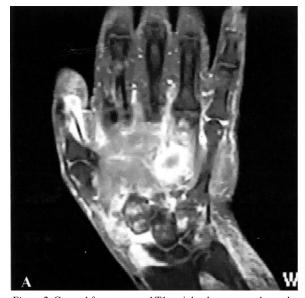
Coronal fat-suppressed T1-weighted contrast-enhanced scan of the dominant hand showing enhanced inflammatory tissue before (A) and after (B) treatment with adalimumab. A significant decrease of enhanced inflammatory tissue was observed after therapy.
